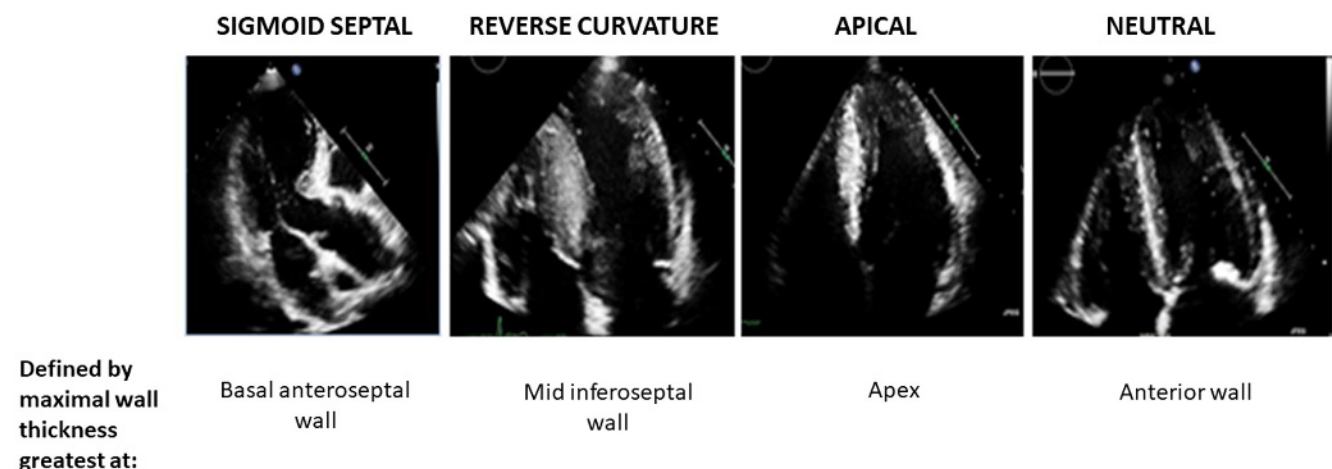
Echocardiographic images are displayed for the four main patterns of hypertrophy, accompanied by the criteria for each pattern.
